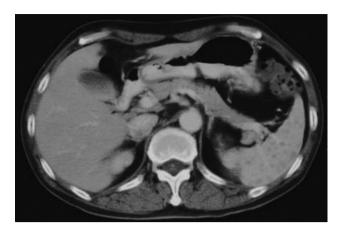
Computed tomography of the abdomen showing multiple nodules in the spleen.
